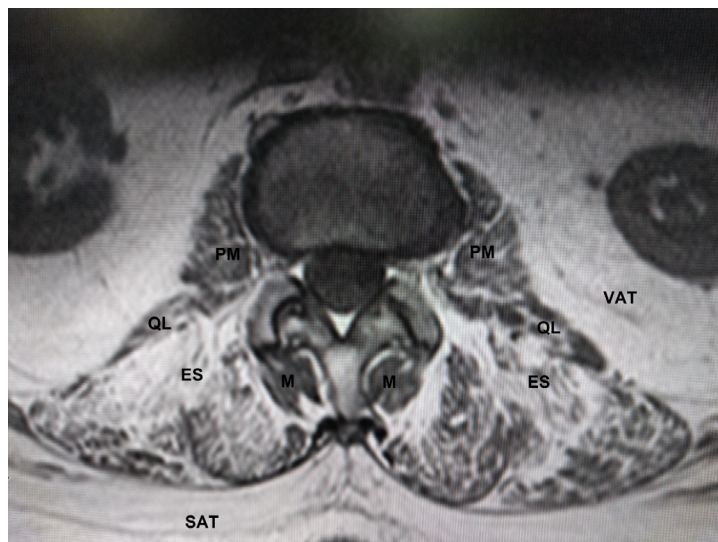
Axial MRI of the lumbar spine - T1 weighted image at the L1/2 level
